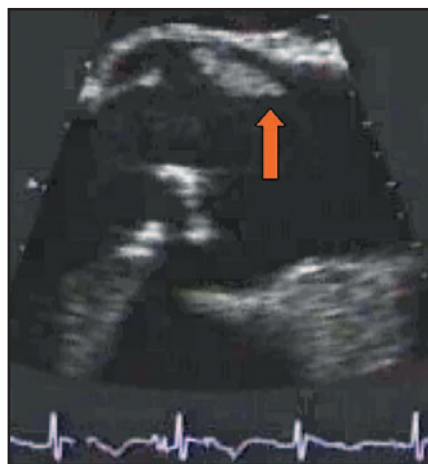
A transesophageal echocardiogram shows a large mobile vegetation (arrow) adherent to the aortic valve leaflet as seen during systole.
